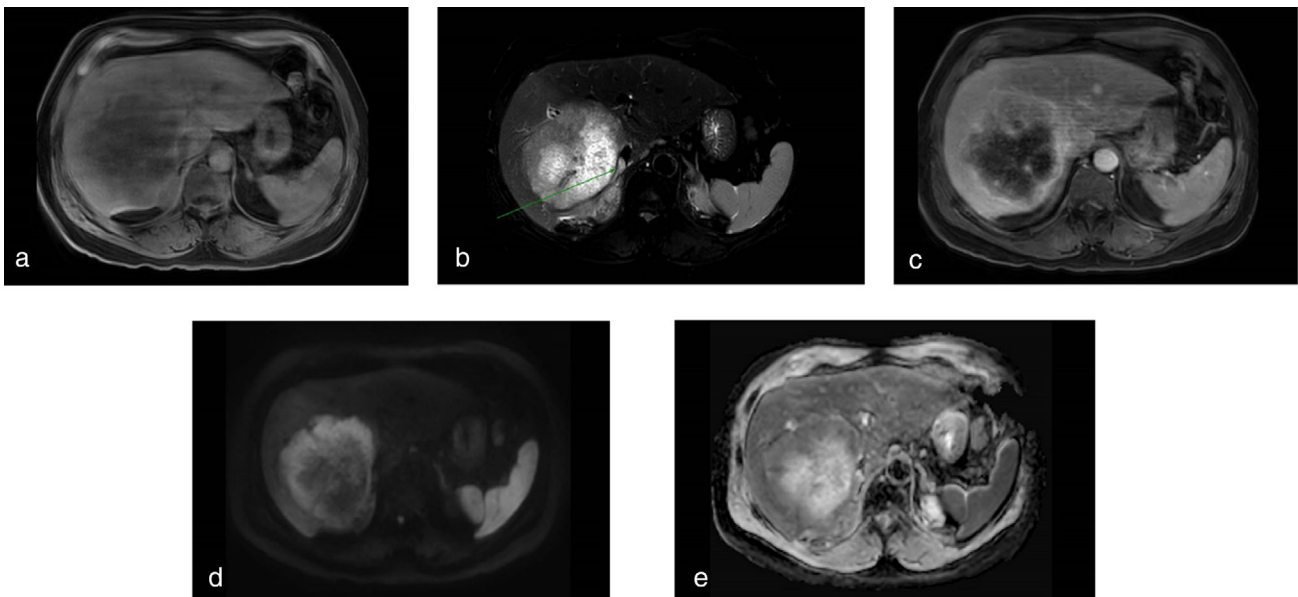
MRI liver (with gadolinium) of case 2. (a) Axial T1-weighted image. (b) Axial T2-weighted image showing large hyperintense lesion, with arrow denoting tumor thrombus in inferior vena cava. (c) Axial contrast-enhanced T1 image (at 4 min) demonstrating delayed-phase enhancement. (d) Axial diffusion-weighted image (b value = 1000 s/mm^2) and corresponding apparent diffusion coefficients (ADC) consistent with peripheral restricted diffusion signal.
